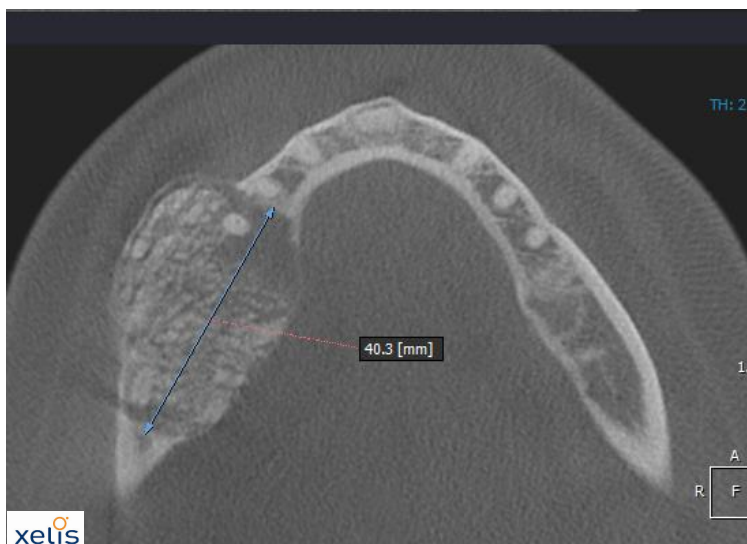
Initial CBCT (Axial slice through lesion with measurement).
